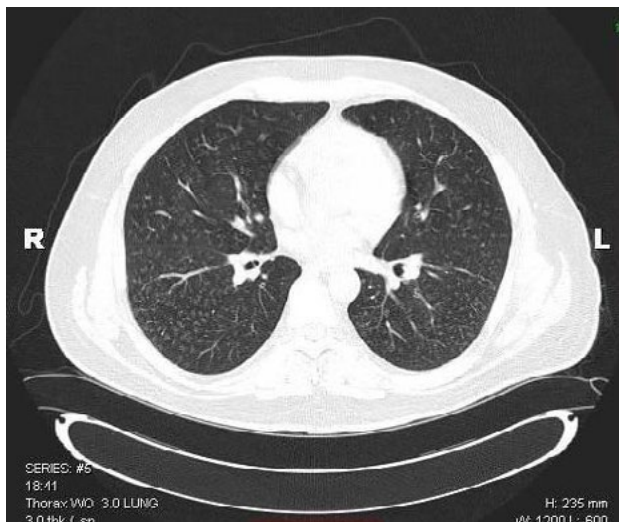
Computed tomography of the chest demonstrates a miliary reticulonodular pattern presumed to be due to bronchiolitis related to smoking marijuana.
